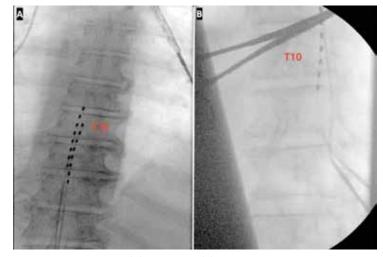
Anteroposterior (A) and lateral (B) radiograph view lead placement at the bottom of T8 and middle of T9 during the second SCS placement in 2023.
